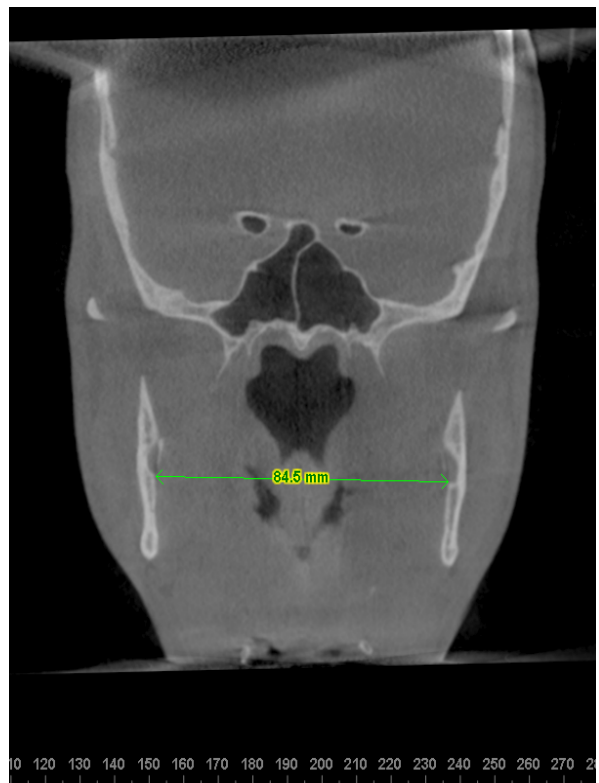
CBCT slices of posterior landmarks
